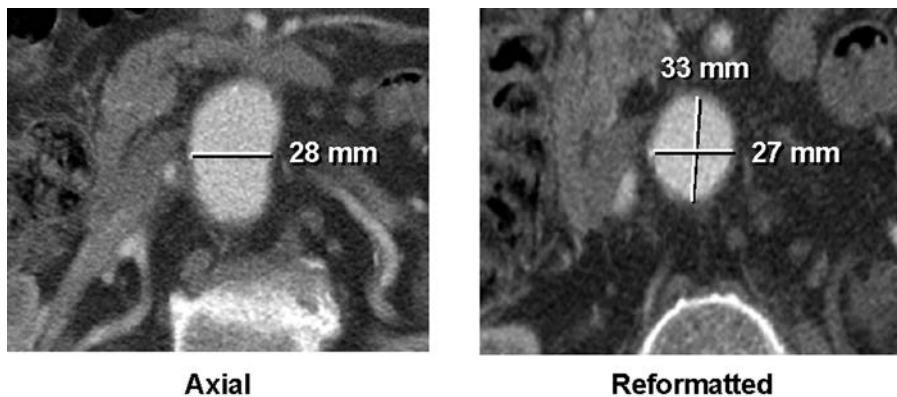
Two CT slices from the same patient's infrarenal aortic neck obtained through 3-D post processing by commercial software (Medical Metrix Solutions, West Lebanon, NH). On the left is an axial slice showing the elliptical artifact caused by angulation of the aorta through the CT plane. On the right is a CT slice at the same location in the neck that has been reformatted to be orthogonal to the vessel. The infrarenal neck is actually not round as shown in the reformatted slice, and there is a significant difference between the maximum and minimum diameters.
